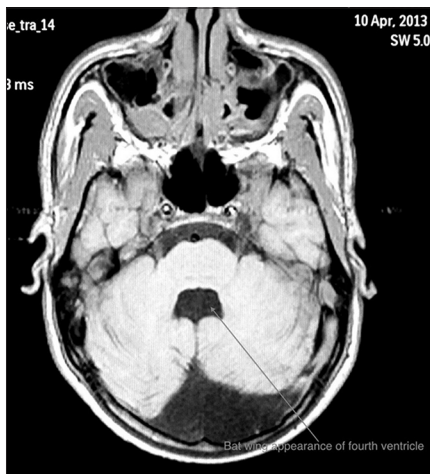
Axial T1-weighted image showed “bat-wing” appearance of the fourth ventricle
